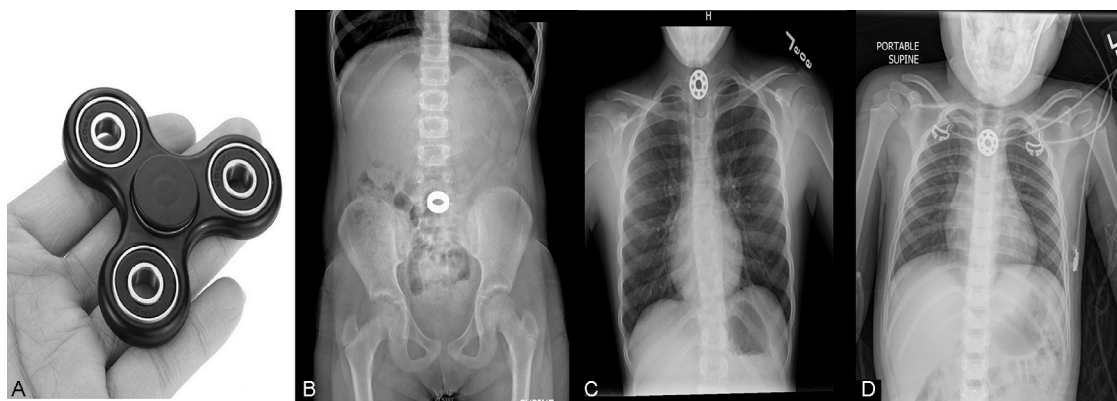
Fidget spinner toy image (A) with anteroposterior plain radiographs (B-D) for cases 1 to 3, respectively. A, Photograph of a generic fidget spinner toy in the palm of an adult male. B, A metal foreign body present in the mid-abdomen overlying the L5 vertebrae. The foreign body is shaped like a cylinder measuring 2.5 cm in diameter by 1 cm in height. C, A 2.5-cm pinwheel-like density within the lower cervical esophagus with 3 mm of soft tissue thickening between the esophagus and trachea. D, A 2.5-cm round foreign body within the upper thoracic esophagus.
